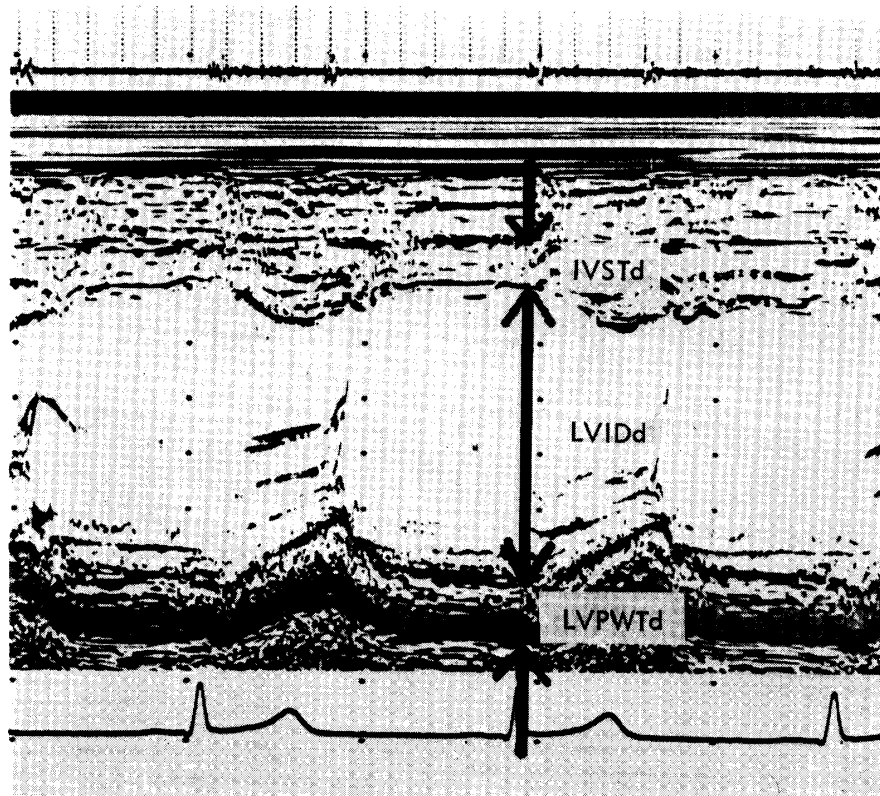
Echocardiogram of Case 9, 14-year-old boy with moderate hypertension (166/100). LVMV is markedly increased (163.2 ccm).
